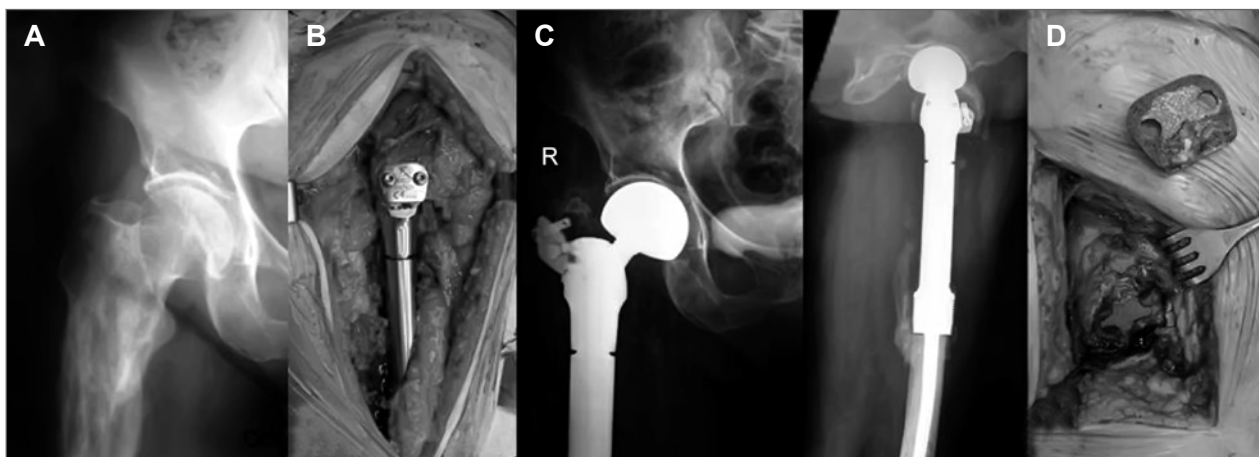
A: Radiograph of the right hip of a 69-year-old woman with lung cancer metastatic to the right proximal femur (Patient 22). B: *En bloc* tumor resection and reconstruction using a proximal femoral megaprosthesis. C: Mechanical loosening of the trochanteric plate was observed 12 months postoperatively. D: The trochanteric plate and screws were removed.
